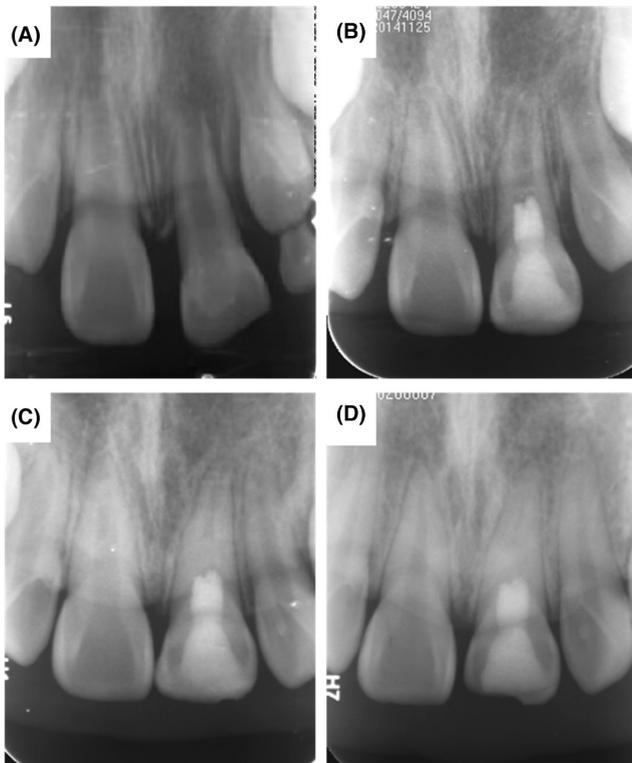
A 9-year-old male patient diagnosed with symptomatic apical periodontitis. Periapical films of tooth 21 over a 73-month follow-up duration. (A) A preoperative periapical film showing an incompletely developed root with an extensive apical radiolucent area. (B) A 4-month follow-up periapical film showing complete resolution of the apical lesion: a calcific barrier formed in the canal between the coronal sealing material and the root apex, and the root continued to develop. (C) A 19-month follow-up periapical film: the root achieved complete development, and the extent of calcification increased. (D) A 73-month follow-up periapical film: severe root canal calcification (obliteration) occurred.
